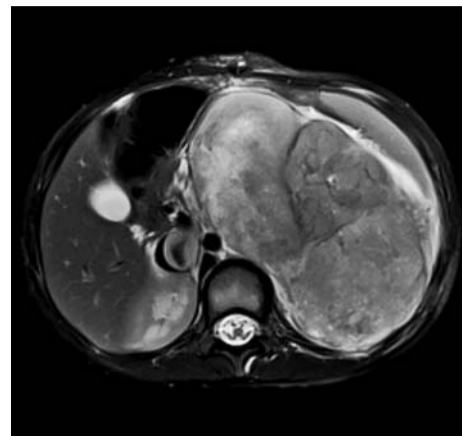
Axial MR image in a 5-year-old male with a left renal tumour and IVC tumour thrombus for biopsy and central venous access
